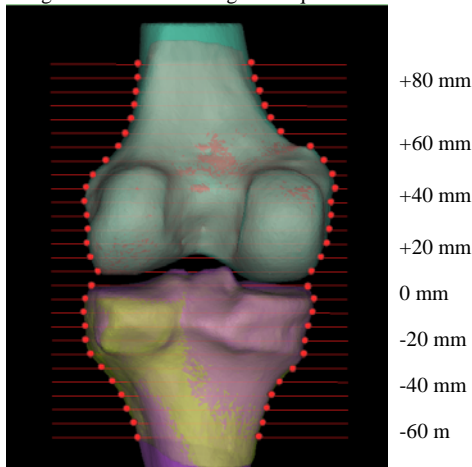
Registered 3D geometries created from CT and MRI data were used to calculate the discrepancies in dimensions at 5 mm intervals both superior and inferior to the joint line.
